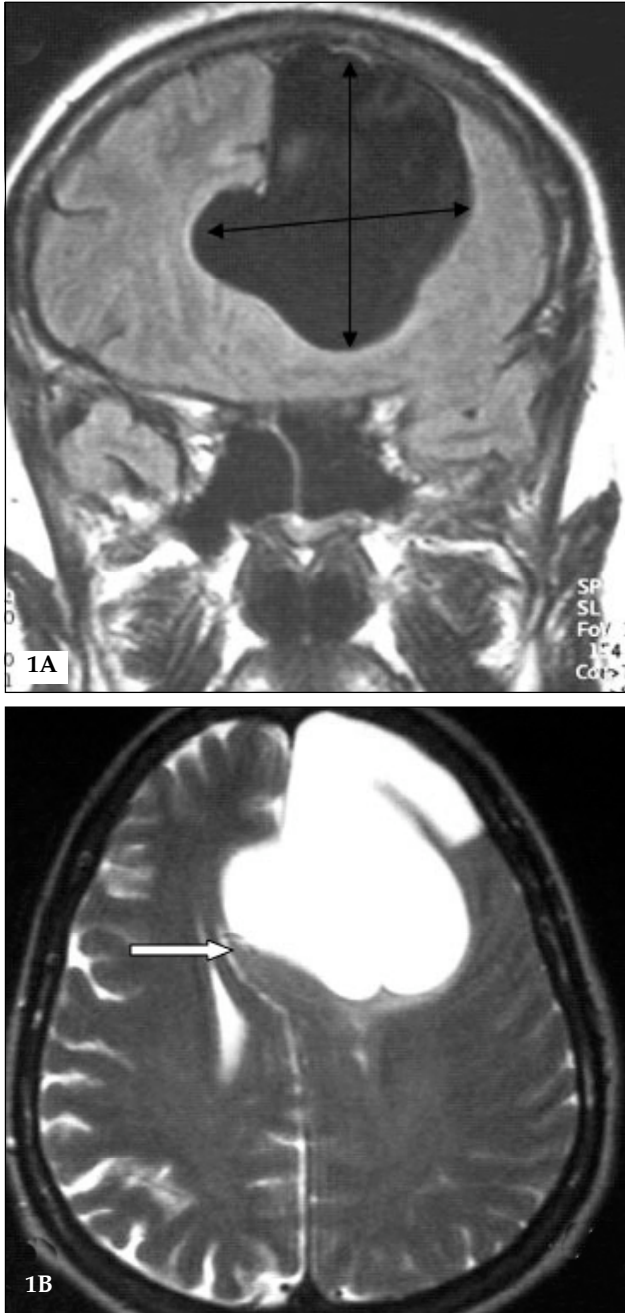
A subsequent MRI revealed a left cystic lesion which was believed to be compressing and shifting the contralateral hemisphere (Fig. 1A, B).
